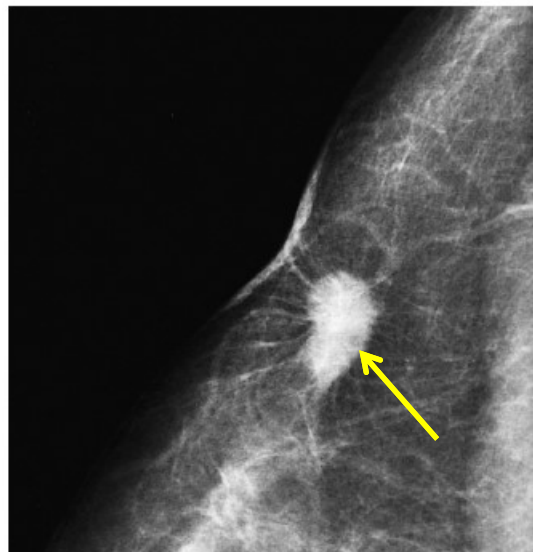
Invasive ductal carcinoma, not otherwise specified (IDC, NOS). Close-up of mammogram with x-ray beam tangential to the area of skin retraction shows the underlying oval, spiculated, high density mass representing carcinoma [146].
